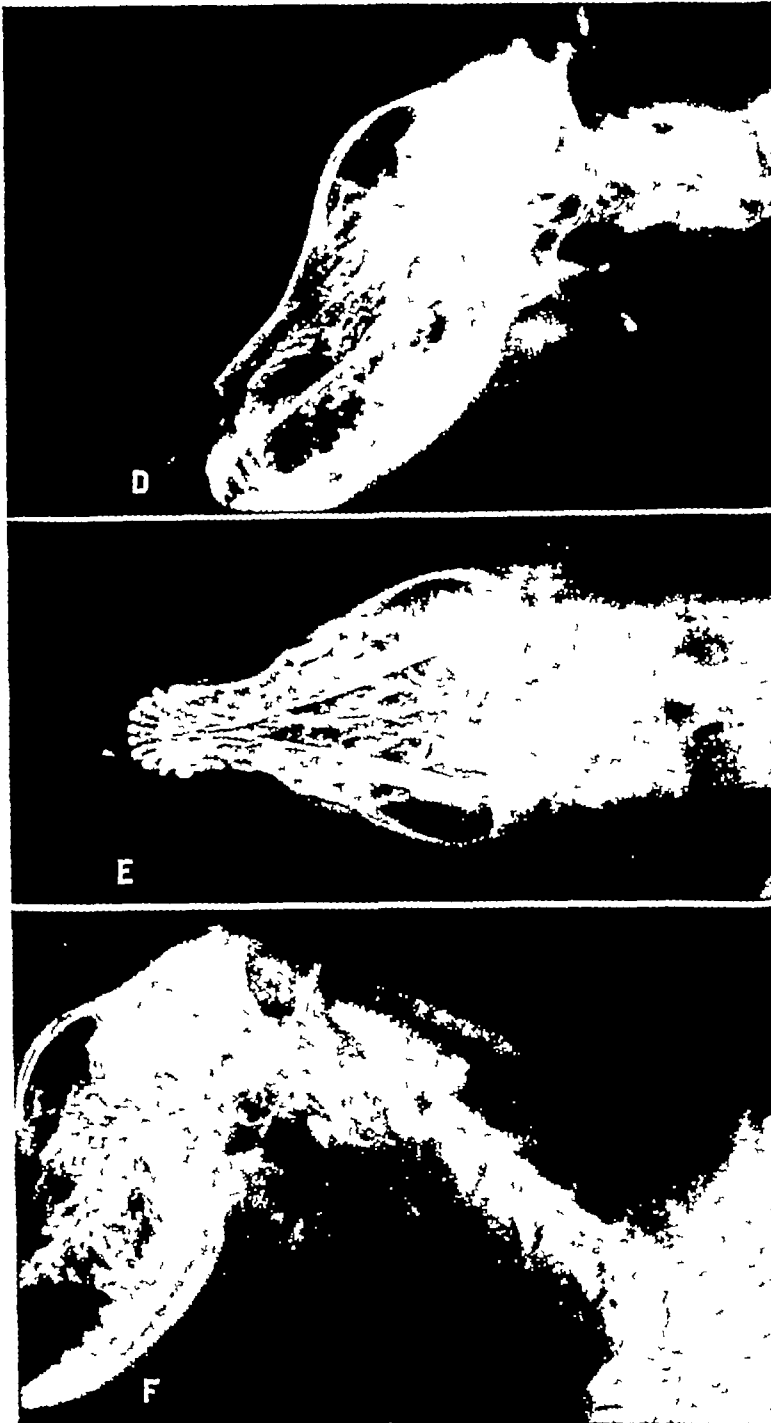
D Visualization of a number of lymphatics as well as the tissues of the nasal cavities 390 minutes after injection E Dorsoventral view showing visualization of the optic nerves 390 minutes after injection The medium may be present in the so-called perineural spaces F Roentgenogram taken two days after the injection, note the small amount of Pantopaque remaining in the cranial cavities and the accumulation of opaque medium in the lymph nodes of the head and neck
